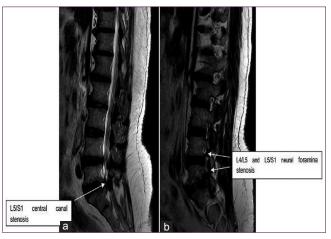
Multilevel disc degeneration, disc bulge, central and exit neural foramina stenosis in a 58 years old male patient referred for lumber magnetic resonance imaging at NSCB
